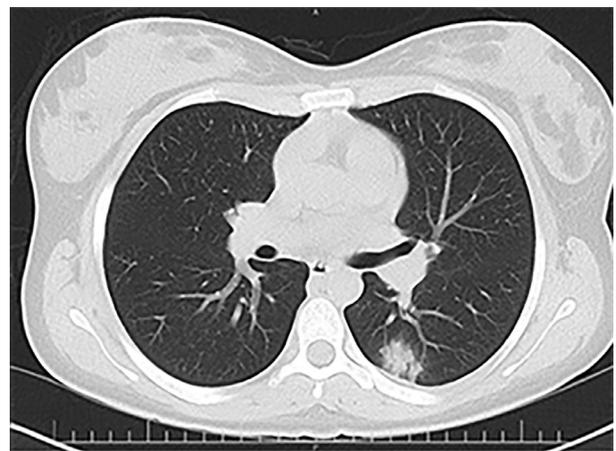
A 14-year-old girl with COVID-19. CT image shows focal subpleural Ground-glass opacifications (GGO) with superimposed consolidation in the left lower lobe.
